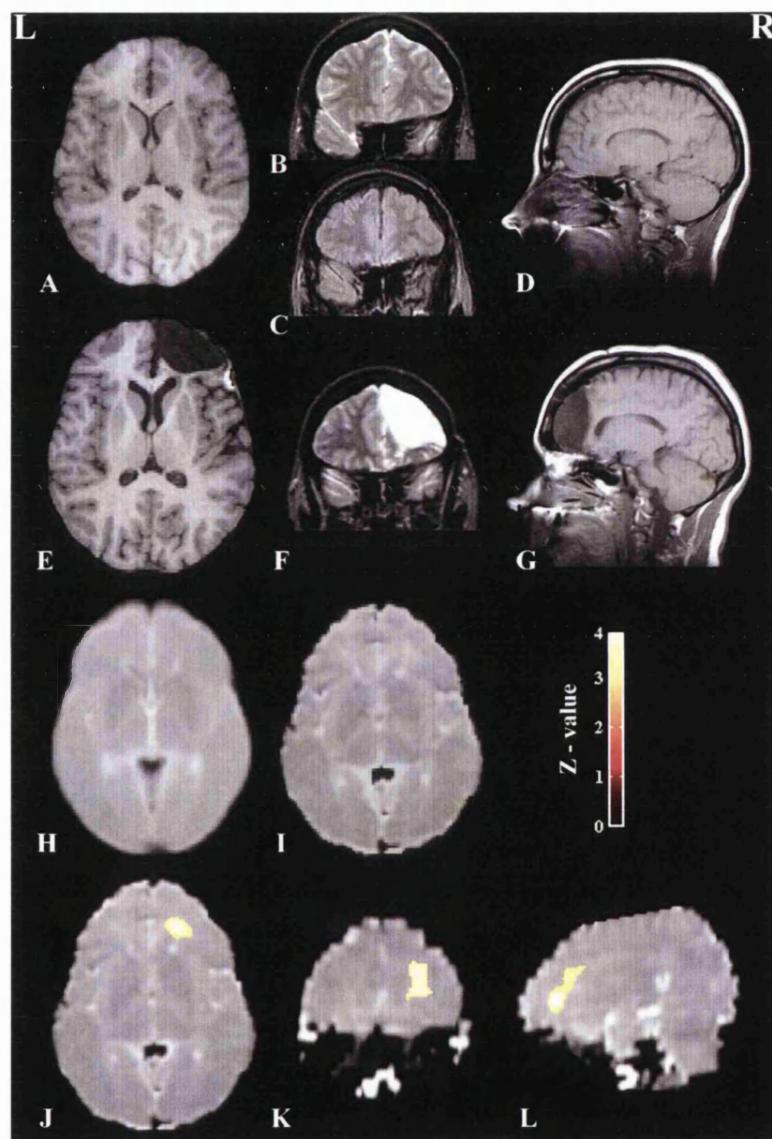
Axial T1-weighted (A), coronal T2-weighted (B), coronal fast FLAIR (C), and sagittal T1-weighted (D) preoperative images, and equivalent postoperative slices of T1- and T2-weighted images (E–G) showing extent of resection; normalized axial diffusivity maps at same slice position for averaged 30 controls (H) and patient (I); region of greatly increased diffusivity superimposed on patient's normalised axial (J), coronal (K) and sagittal (L) diffusivity maps. Region highlighted in (J) was used for quantitative region-of-interest analysis of diffusivity values. Note that right on images is patient's right. Z-value bar indicating degree of significance of highlighted regions in J–L is shown.
